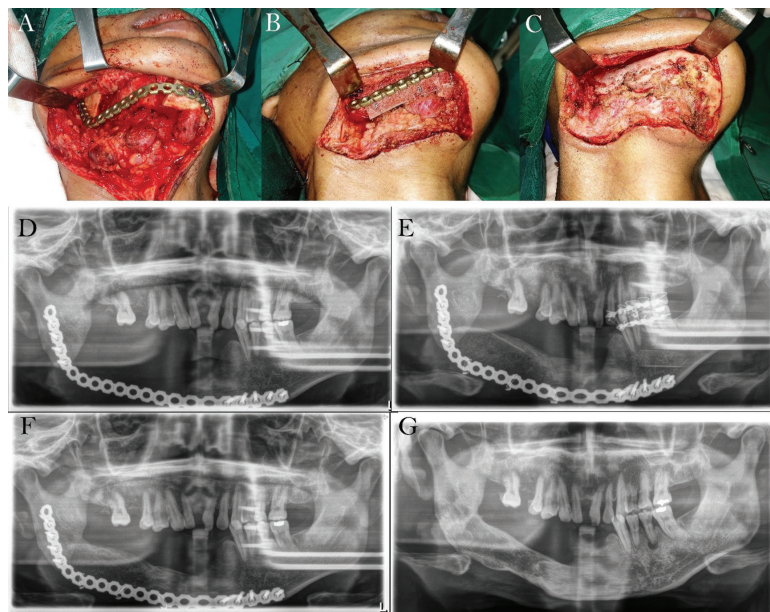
A. A 2.4-mm locking-type reconstruction plate stabilizes the mandibular defect after tumor resection. B. A delayed nonvascularized iliac bone graft was performed 72 days after tumor resection. C. A nonvascularized bone graft was performed 185 days after plate removal. D. The radiographic examination reveals a 2.4-mm locking-type reconstruction plate that stabilizes the mandibular defect following tumor resection. E. The radiographic examination indicates that a delayed non vascularized iliac bone graft was conducted 72 days following tumor resection. F. The radiographic examination demonstrates incorporation of the iliac bone graft at 178 days. G. The radiographic examination revealed the transplanted bone at 242 days.
